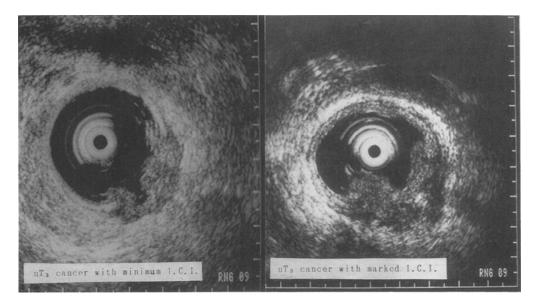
Ultrasonograms showing uT3 cancer. Left. The layer of muscularis propria is invaded by the tumor completely, and the outermost hyperechoic band disappears in the central area of the tumor. Right. The tumor is surrounded by hypoechoic bands produced by inflammatory cell infiltration (I.C.I.), so that the outermost band disappears even in the peripheral area of the tumor, where cancer invasion does not exist.
